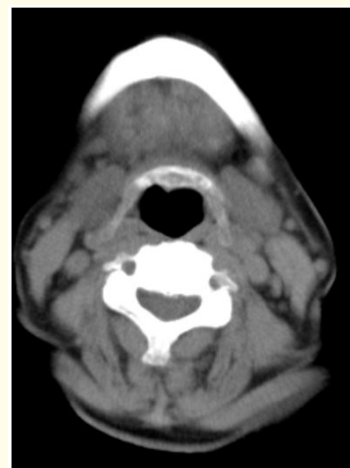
High-resolution computed tomographic scans of neck showing gas resorption.
